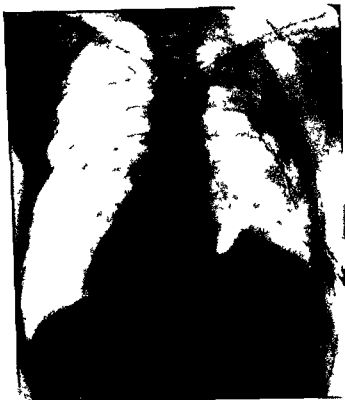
Roentgenogram showing narrowing of track 6 weeks after suction
